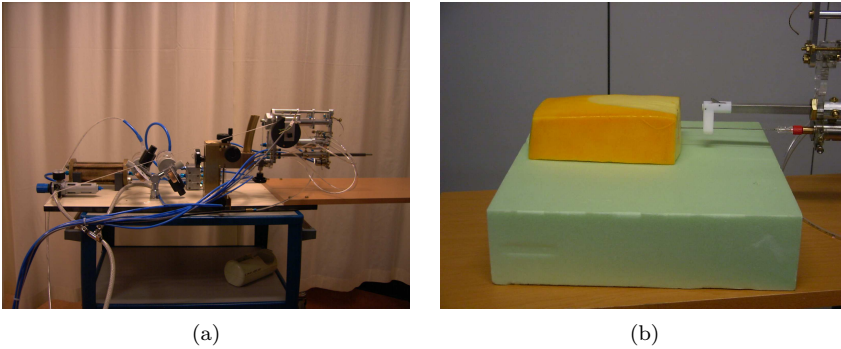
Pictures of (a) the robotic device used during the MRI compatibility tests and (b) the experimental setup with the piece of cheese
